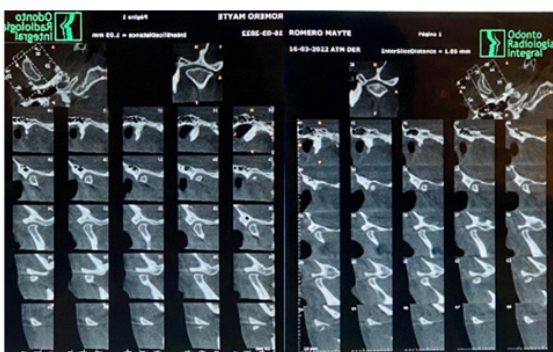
Patient M.R. CT scan of right and left TMJ.
